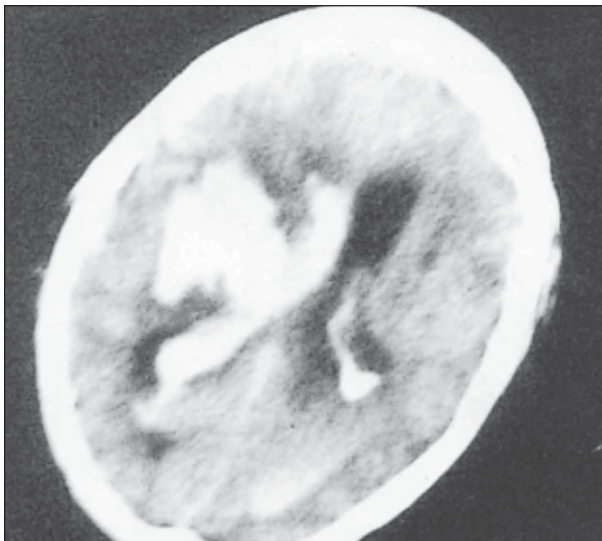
CT-Scan of brain showing right sided large intracerebral haematoma with ventricular extension at right MCA territory.
